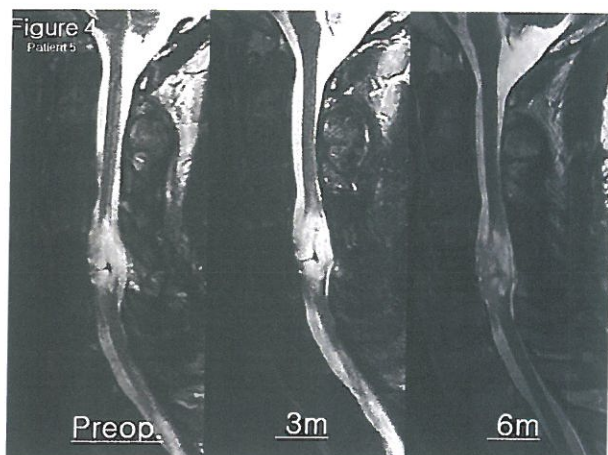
In Patient 5, there was a thickening of the proximal cord above the level of the injury in T2 weighted image of the follow-up MRI.
